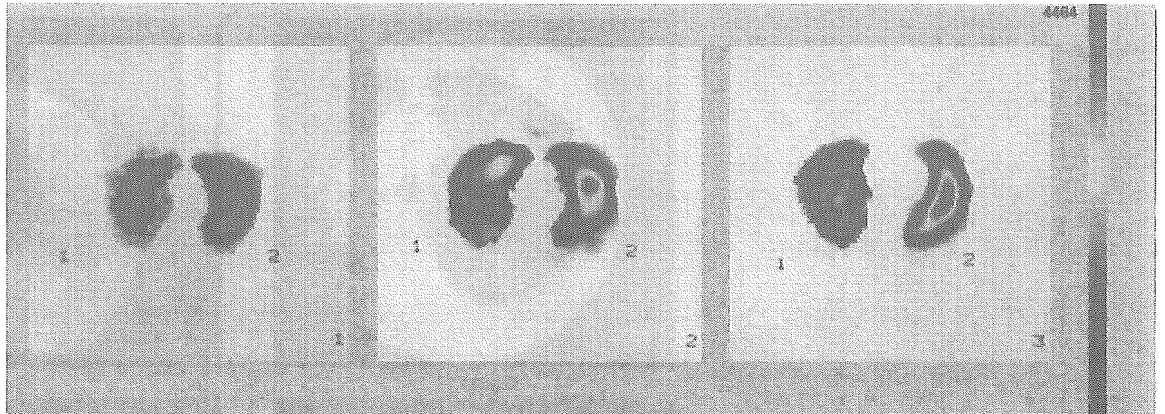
The SPECT image for one case (M.T.). The lungs were divided into an upper, a middle and a lower part from the left. Red and yellow areas had a better pulmonary blood flow than blue areas.
